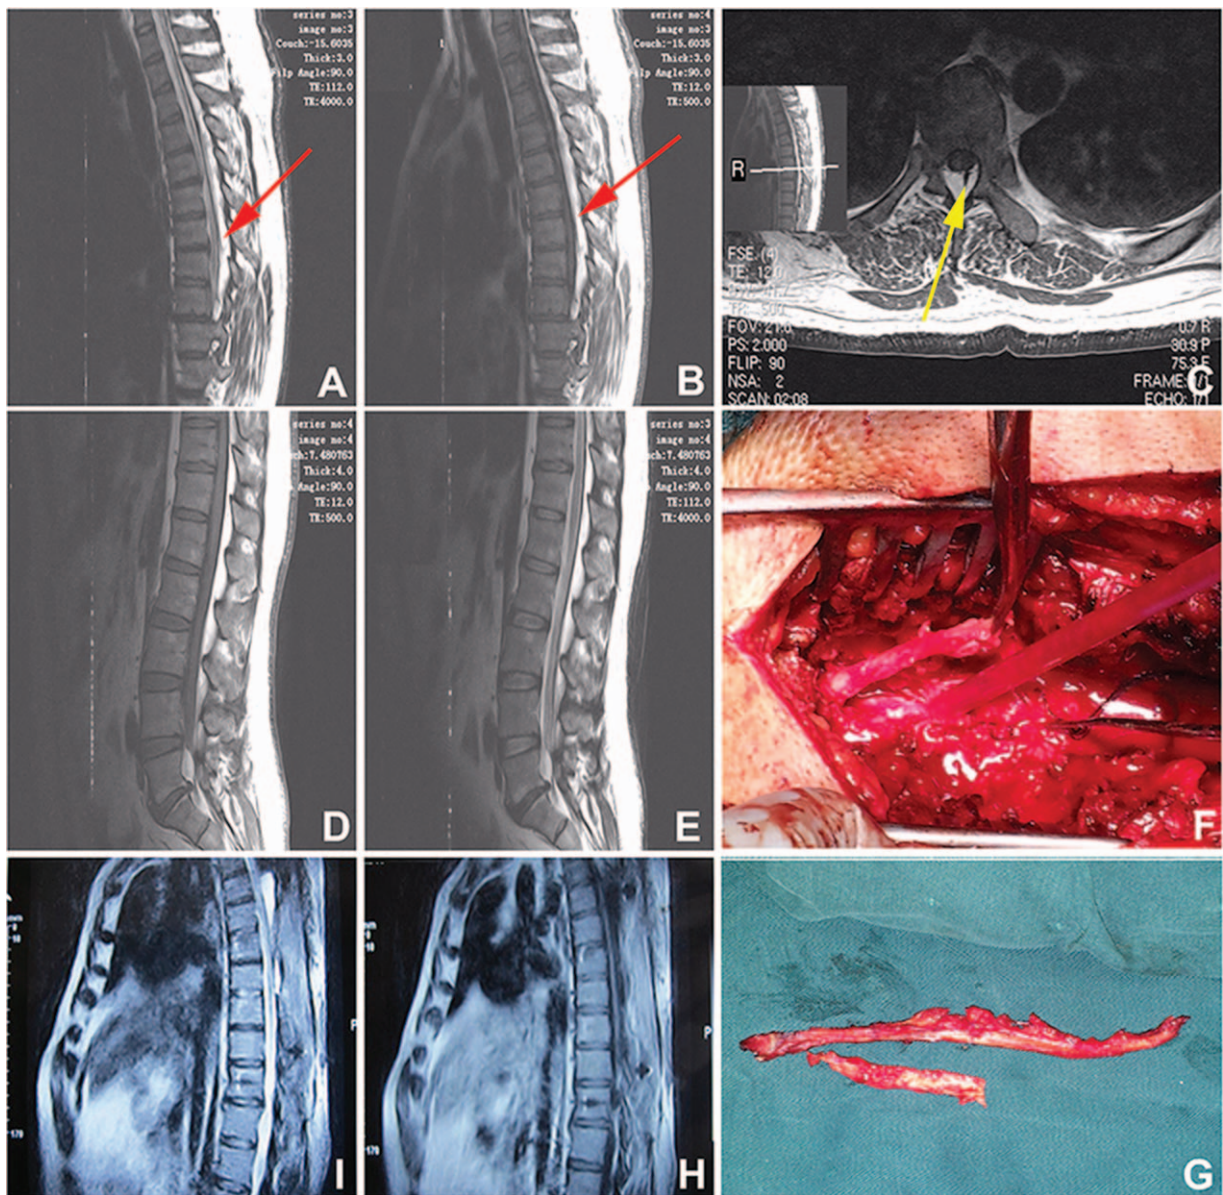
(A–C) Sagittal-plane MRI of the thoracic vertebral body suggested the spinal cord atrophy from C7 to T5, epidural lipoma or angiolioma observed from T1 to T10, and fibrous strip signal from the left dural sac to the dorsal space. (D, E) Fibrous strip extended to L4 revealed by lumbar vertebra MRI. (F, G) The fibrous strip was raised and resected. (H, I) MRI revealed that dural sac and spinal cord compression disappeared 10 months after the operation.
